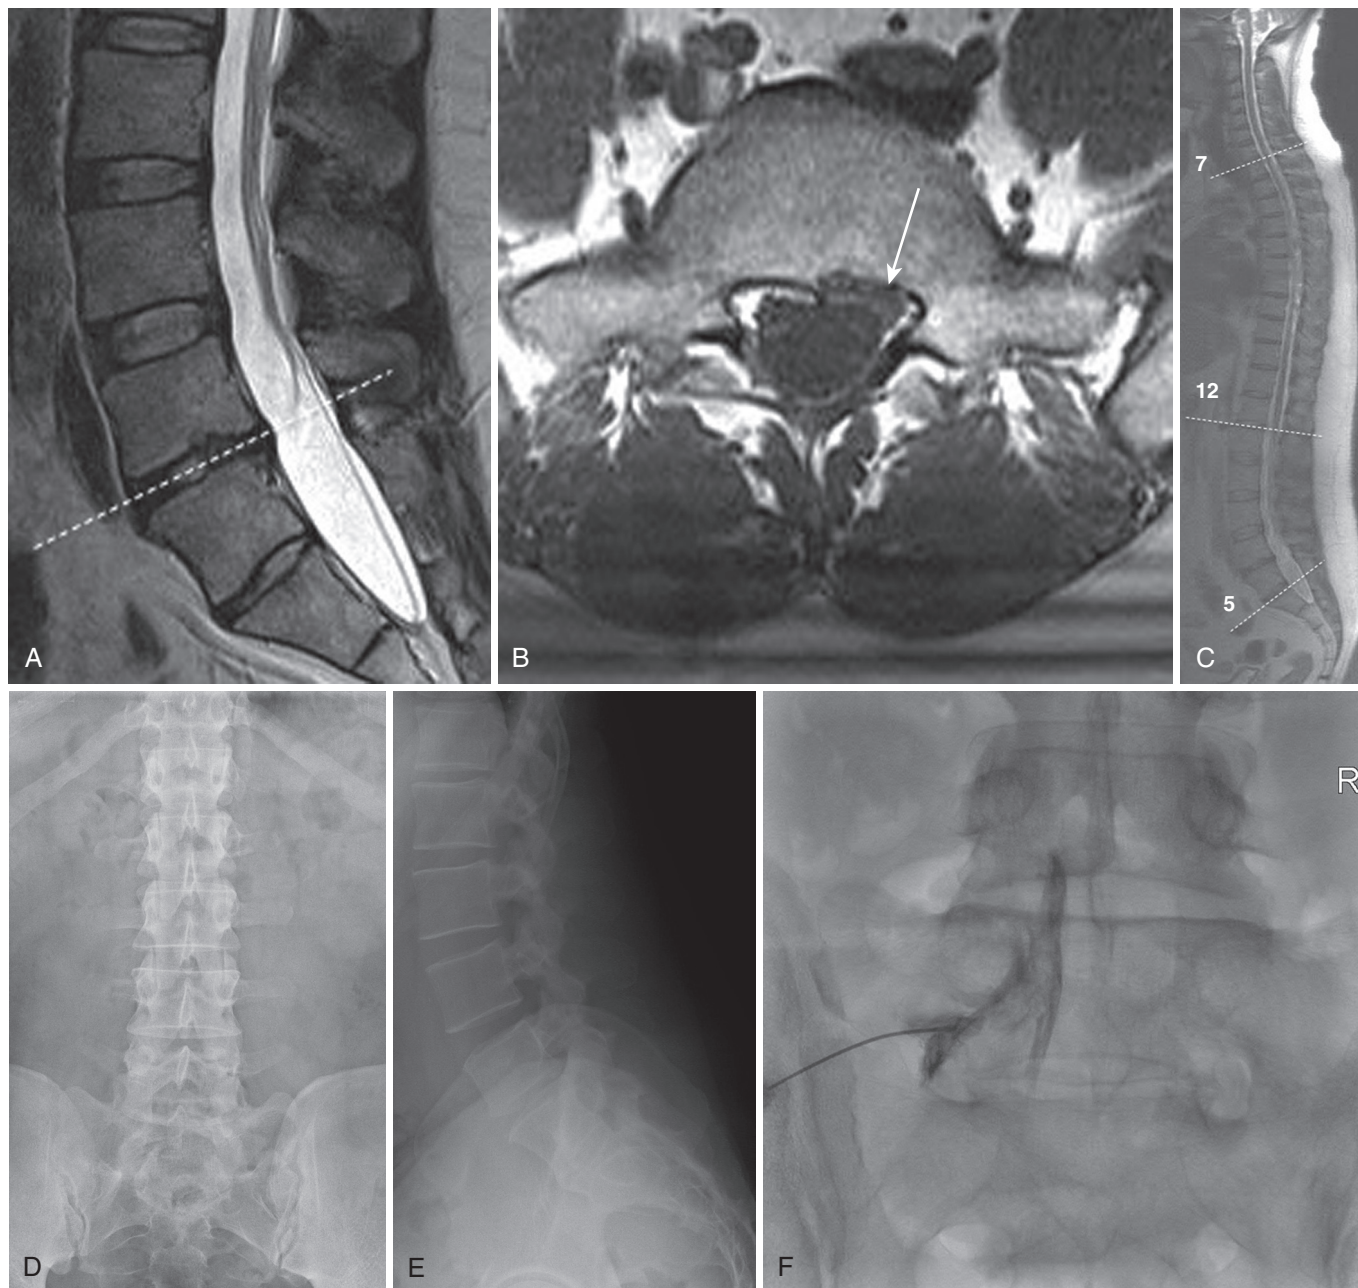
The importance of segmental enumeration. This 36-year-old male who has failed conservative care presents with a left-sided L5 radicular pain pattern involving the lateral thigh, lateral calf, and dorsum of the foot. His MRI (sagittal T2 [A] and axial T1 [B] at level of dotted line) shows a subtle disk extrusion in the left lateral recess (arrow in [B]) at the penultimate interspace. The lowest-most disk appears transitional. MRI scout (C) image demonstrates 24 presacral segments. Frontal and lateral radiographs (D and E) may suggest 5 lumbar vertebrae on cursory examination; careful counting at fluoroscopy noted 11 rib-bearing vertebrae. T12 has no ribs and L5 is transitional, Castellvi type 4. The transforaminal epidural steroid injection (F and G) was performed under the pedicle bearing the dysplastic left T5 transverse process and relieved the patient's pain.
